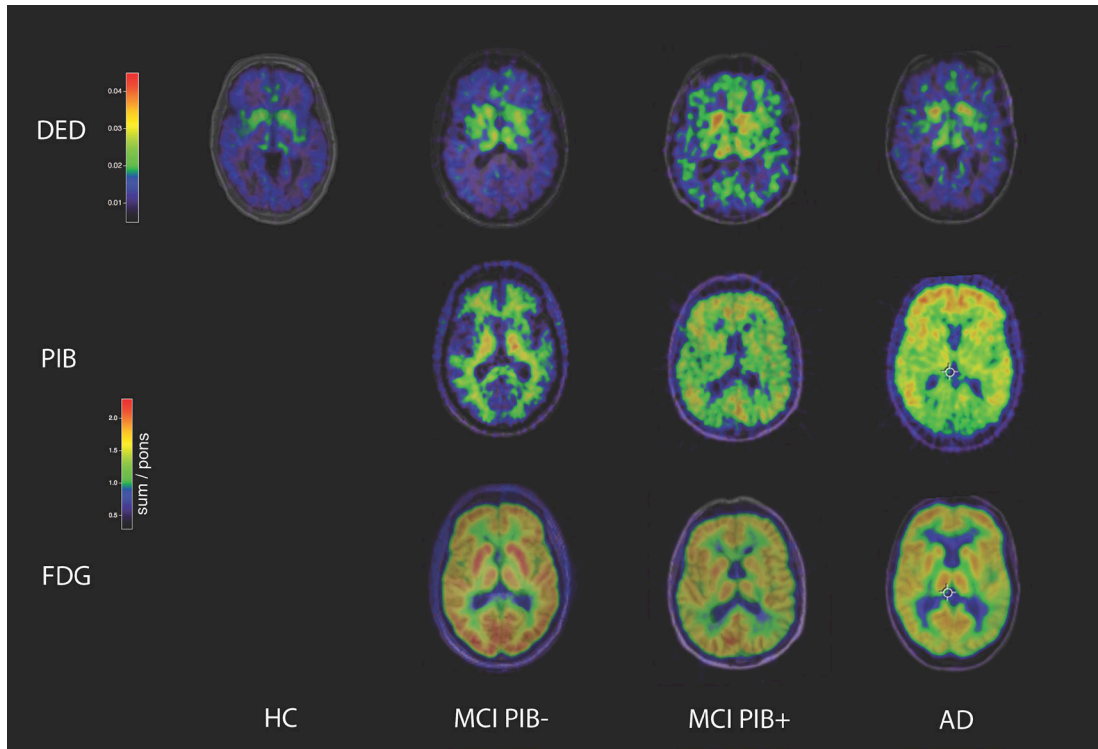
Representative DED slope parametric and PIB and FDG sum/pons images. The MCI PIB+ patient showed the highest diffuse cortical DED binding.
